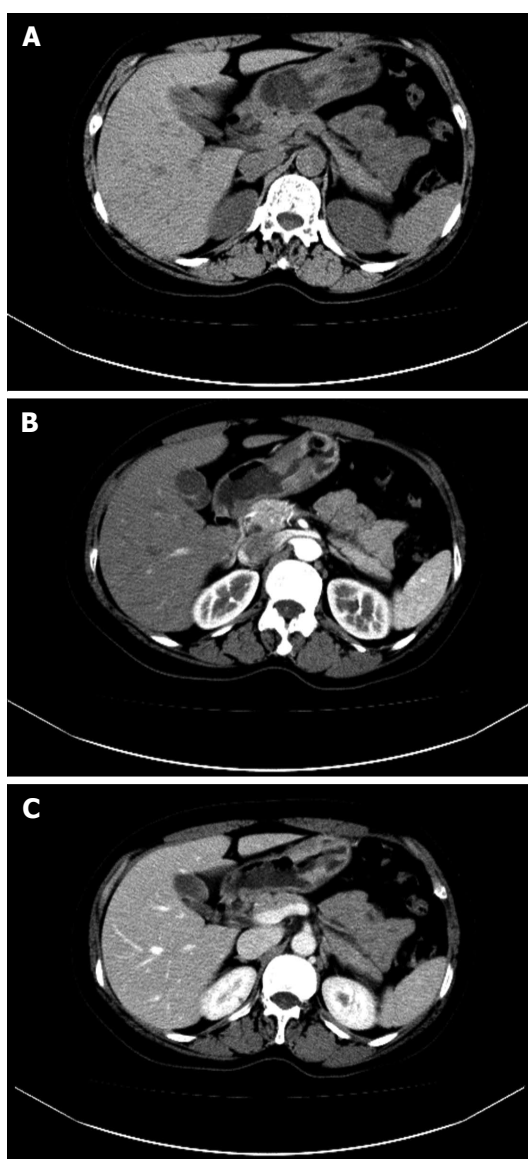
A 56-year-old female patient with early gastric carcinoma. Computed tomography scans showing thickening wall and narrowing antrum of stomach (A), moderate arterial (B) and venous (C) phase enhancement.
